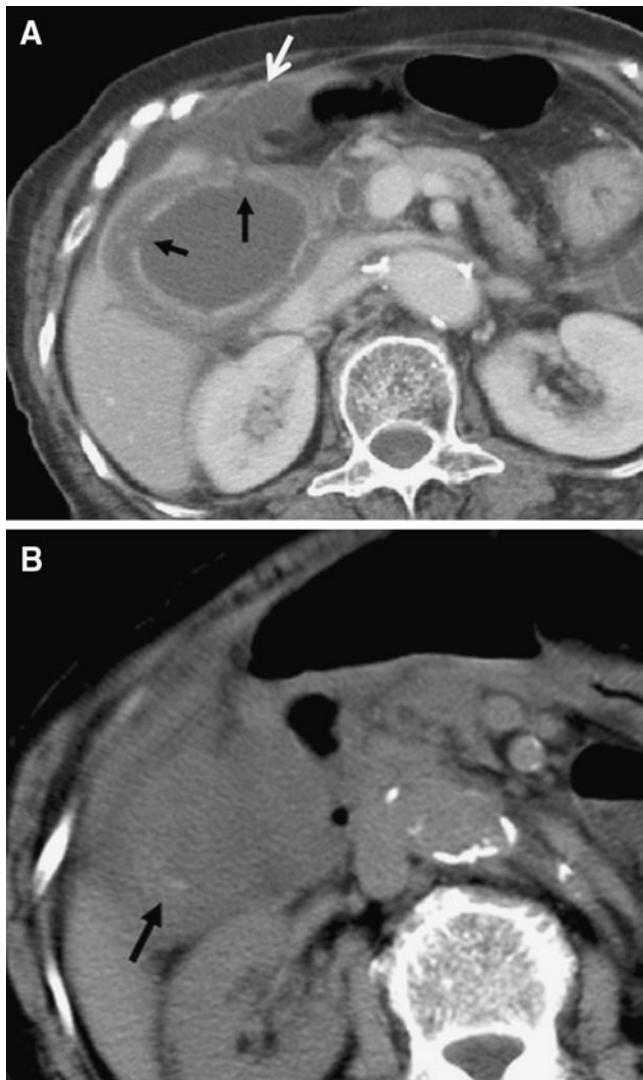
An 80-year-old woman with acute gangrenous cholecystitis. A Axial contrast-enhanced CT image shows discontinuity of the mucosal enhancement with a gap at the gallbladder wall (black arrow) and an irregular wall associated with a pericholecystic fluid collection (white arrow), indicative of abscess formation. B A few centimeters below the structures seen in (A), a focal wall hyperdensity (black arrow) is suggestive of wall hemorrhage.
